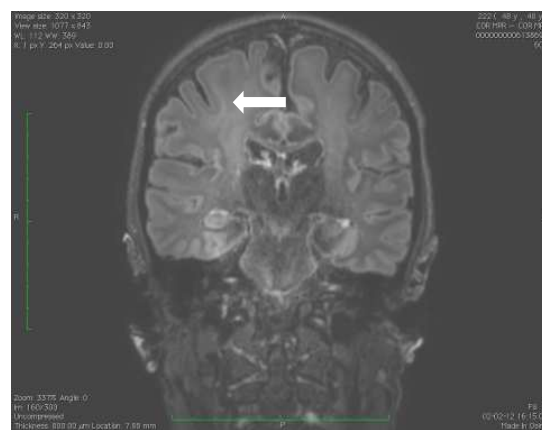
b . same patient: comparison between FLAIR 3 (left) and 7 (right) T images of a patient with known FCD right hand knob to deep-of-the-sulcus
